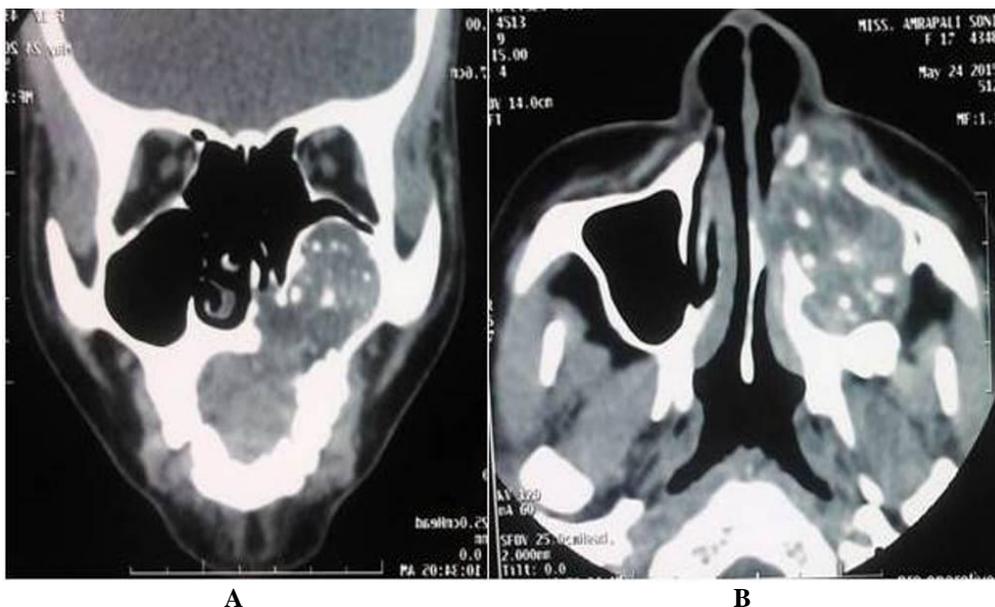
Cone Beam Computed Tomography scan (A) Coronal section showing palatal cortical plate perforation (B) Axial section showing expansile destructive lesion with left maxillary sinus.
